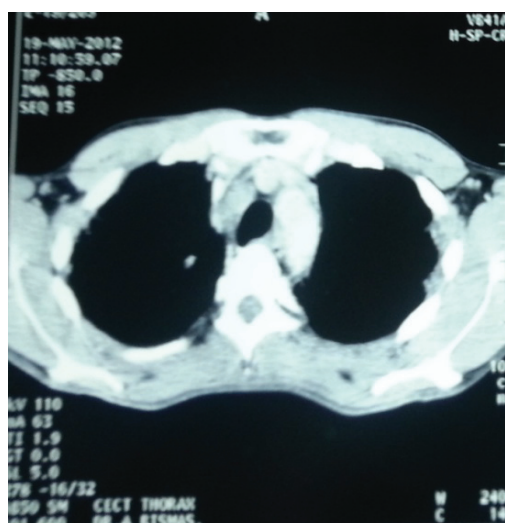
CT chest showing right paratracheal and subcarinal lymph nodes enlargement with caseation
